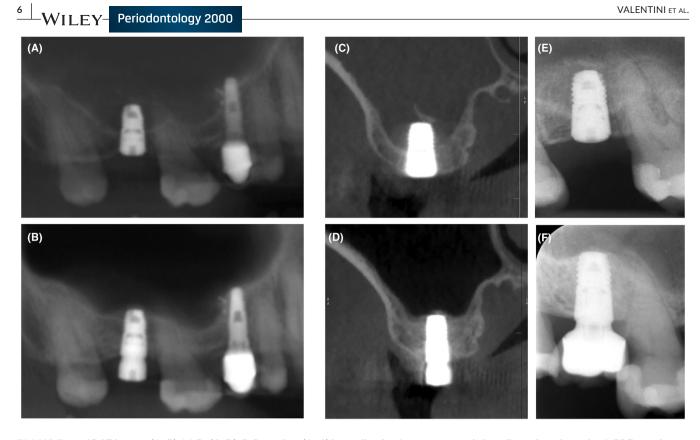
CBCT images (A, B): M-D; (C, D): B-P section, (A, C) immediately after transcrestal sinus floor elevation using L-PRF as sole substitute; (B, D) after 4 months of healing Intra-oral long-cone radiographs; (E): at the day of surgery; (F): 4 years later.
